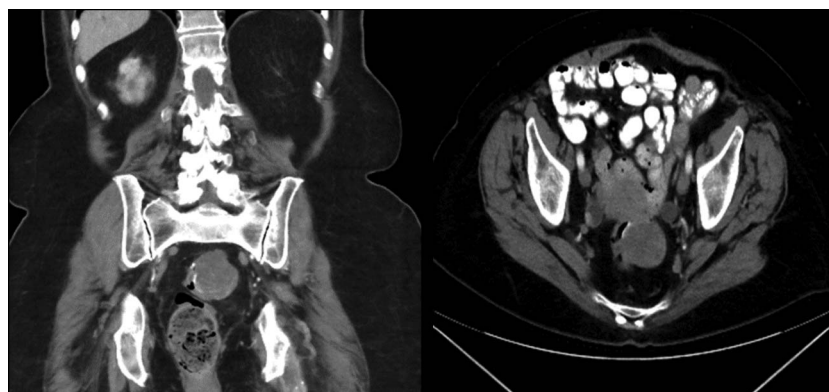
Computed tomography scan showing well-circumscribed perirectal lesion.
